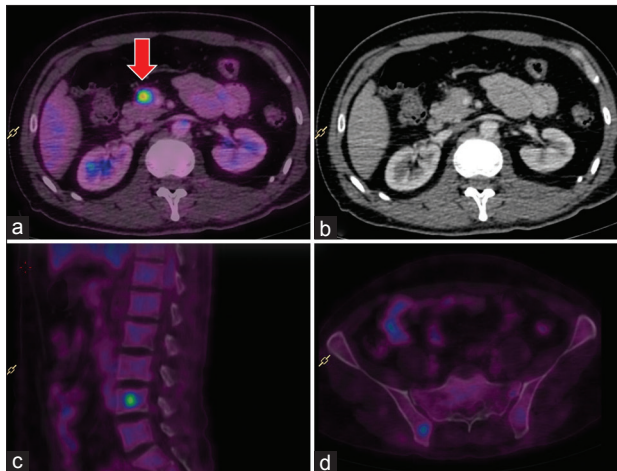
Transaxial view of fused image (a) shows fluorodeoxyglucose avid deposit in the pancreas (arrow), which is inconspicuous in corresponding contrast-enhanced computed tomography image (b). Sagittal view (c) and transaxial view (d) of fused images show focal hypermetabolism in L4 lumbar vertebrae and right iliac bone, respectively. These hypermetabolic foci in aggressive cancer such as rhabdomyosarcoma are suggestive of distant metastases
